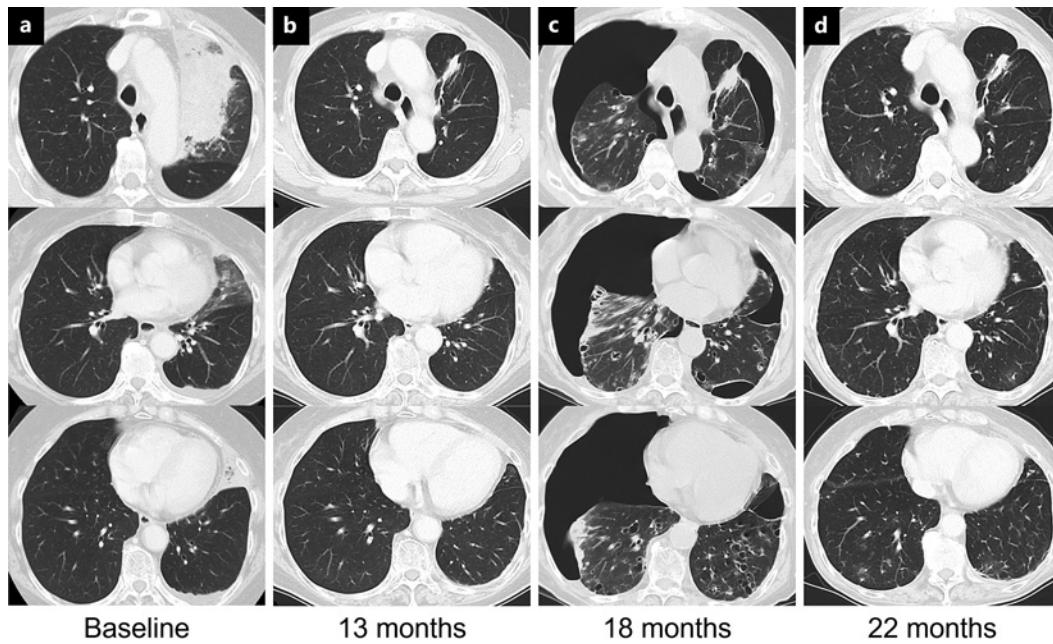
CT scan during chemotherapy CT scan showing the baseline before the initiation of osimertinib (a), the presence of a nodule in the left upper lobe of the lung at 13 months from the initiation of osimertinib therapy (b), the appearance of pneumothorax and diffuse cysts at 18 months (c), and the disappearance of the cysts after four cycles of second-line therapy at 22 months (d). CT, computed tomography.
